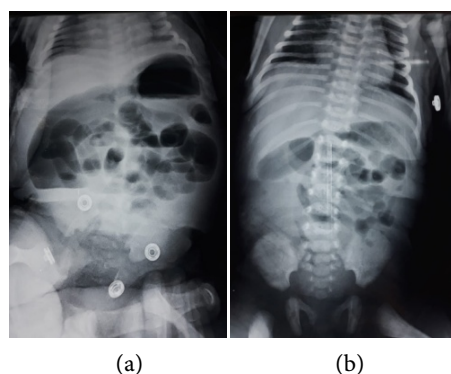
Thoracoabdominal Xrays. (a) Hydro-aeric levels in the colon evoking an occlusion. (b) Disappearance of the hydro-aeric levels after treatment.
